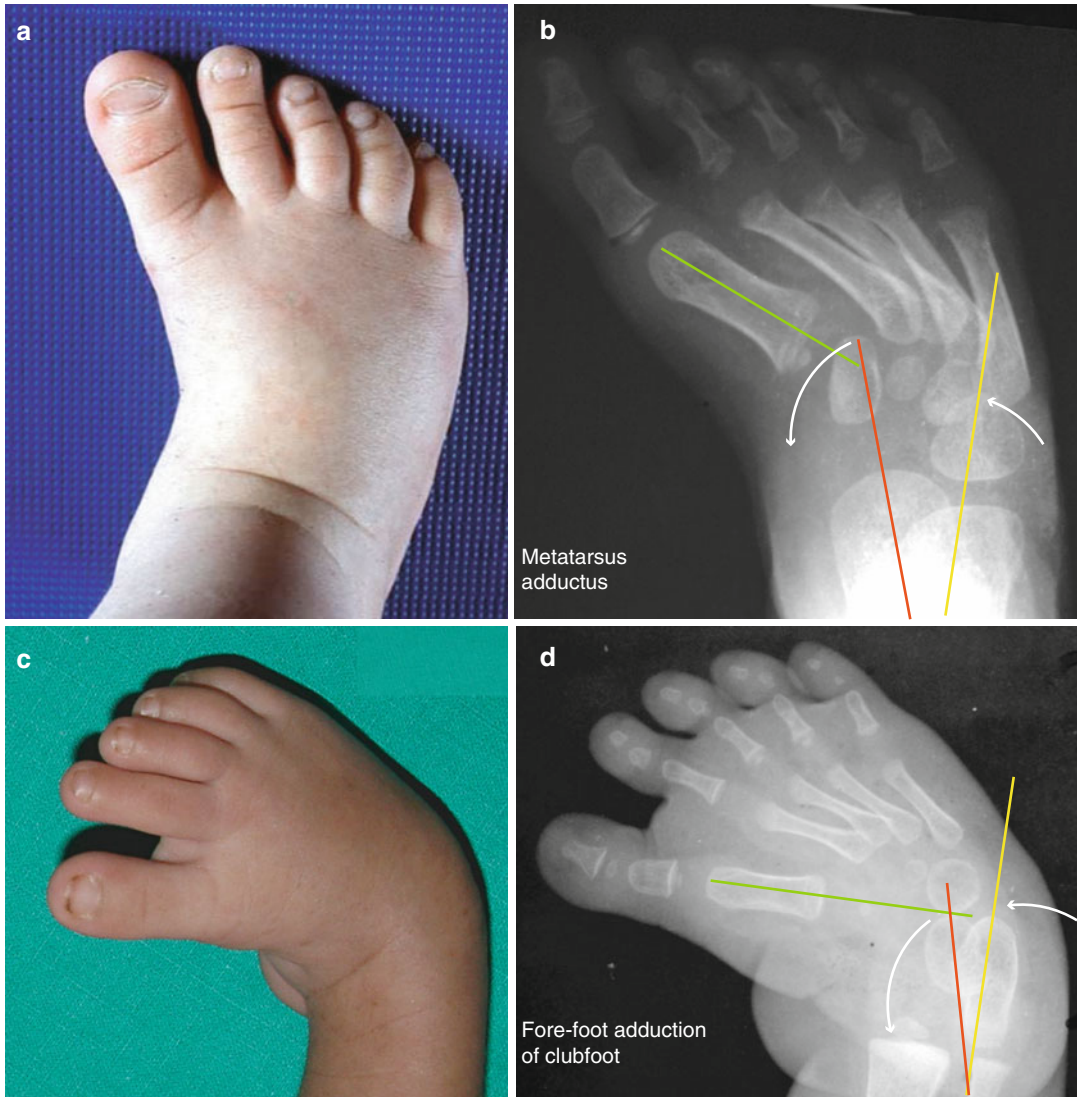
Clinical appearance and radiographs of metatarsus adductus (a, b) and forefoot adduction of clubfoot (c, d). The long axes of the calcaneus (*yellow*), talus (*red*), and the first metatarsal (*green*) are marked. In metatarsus adductus, the long axis of the calcaneus
